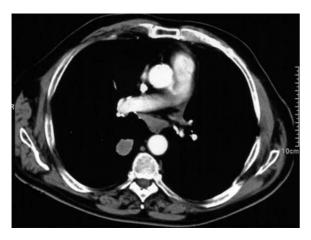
CT-thorax: lung cancer with a diameter of 2.8 cm (T1-tumor) but suspected infrabifurcal lymph node infiltration, that could be excluded by PET and transesophageal ultrasound
